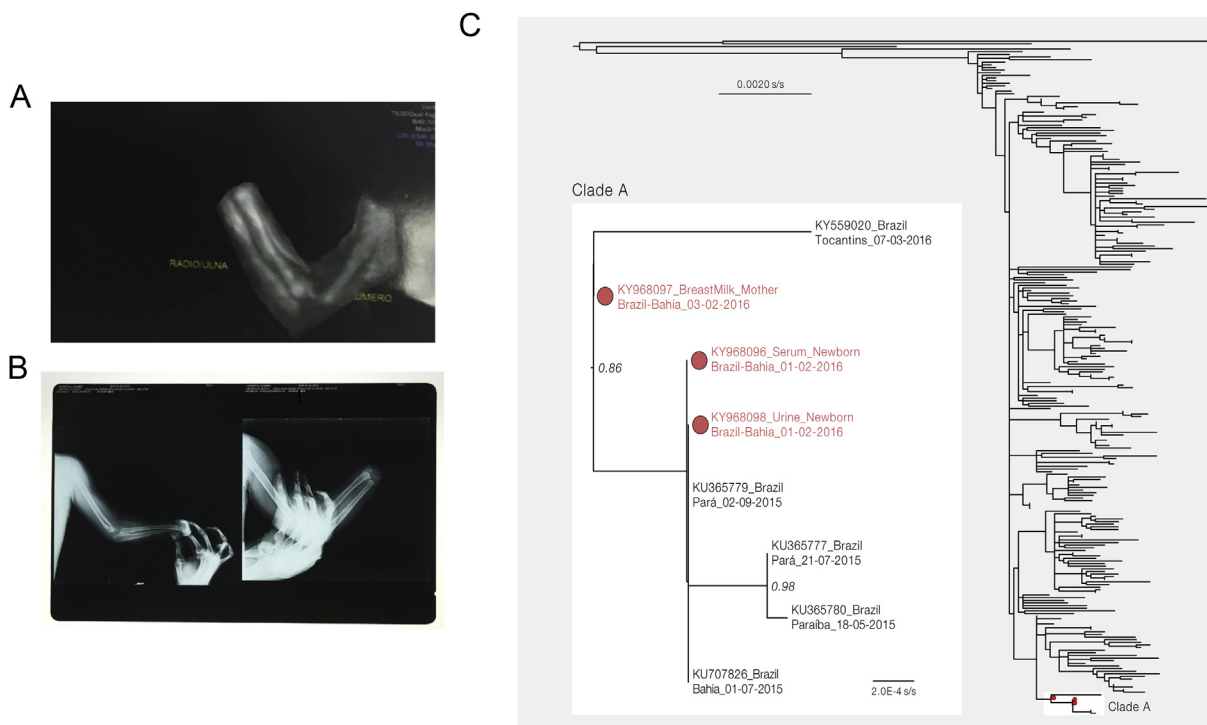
(A, B) Clinical evaluation of congenital abnormalities. (A) Foetal ultrasound performed during 23rd gestational week revealed morphologic alteration in left hand of fetus. (B) X-ray evaluation performed after second year of birth confirmed defect of left upper limb. (C) Phylogenetic analysis of a newborn with congenital defects. Maximum likelihood phylogeny of NS5 sequences. Phylogeny was estimated using PhyML. Data set used contained new sequences recovered from mother's breast milk and from serum and urine of newborn, in addition to 254 publicly available complete genome sequences of Zika virus Asian genotype sampled in South America, Asia, Europe, Caribbean, North America and Pacific Islands. Sequences obtained from present study subjects are highlighted in red. Scale bar is in units of nucleotide substitutions per site. Inset shows close-up view of clade A containing newly isolated strains from Feira de Santana, Bahia (February 2016).
